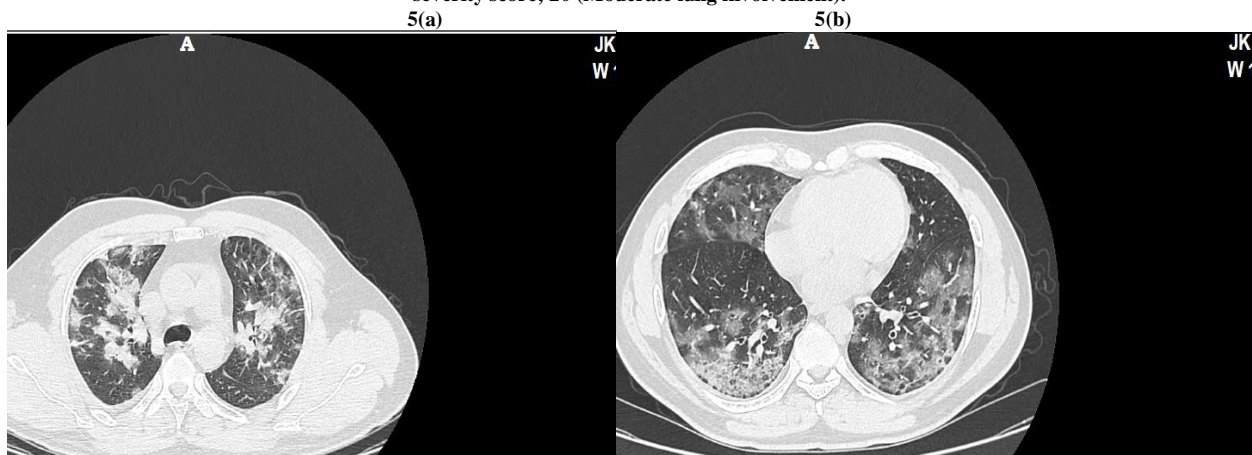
(a)& (b)-HRCT Chest of 17yr old RTPCR positive patient showing halo and reverse halo sign respectively with multiple discrete and confluent patches of GGO. CT severity score; 18 (Moderate lung involvement).
